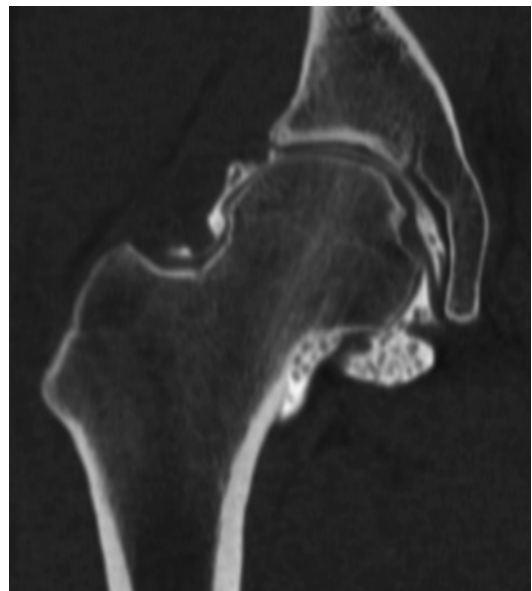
Arthro-CT coronal view of chondromatosis in a right hip
